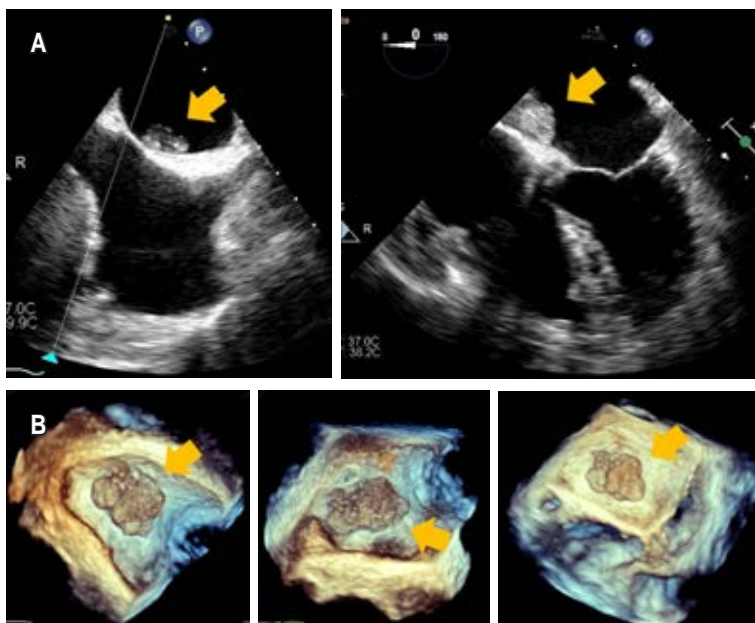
Transesophageal echocardiography. A) Heterogeneous, lobulated mass in the left atrium attached to the interatrial septum. B) Real-time 3-dimensional echocardiography (RT3DE) image.
